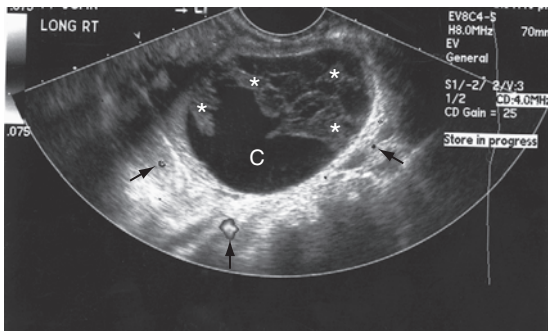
14 Complex cyst. A transvaginal sagittal image of the right adnexa in a female patient demonstrating a cyst (C) containing internal solid echogenic components representing hemorrhage (*). Echogenic hemorrhage within a cystic mass may mimic a malignant tumor: Doppler may be able to detect internal vascularity, which is frequently seen in malignant tumors. Note the presence of Doppler signals outside the cyst (arrows).
